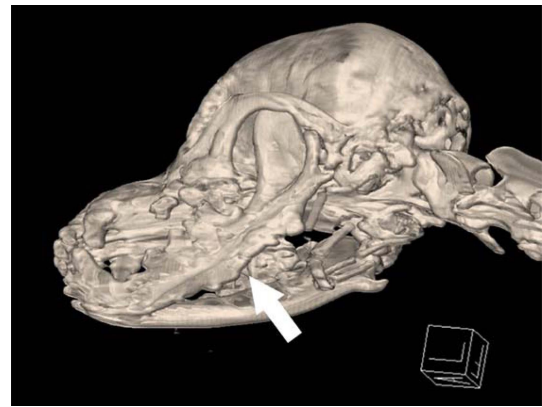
Three-dimensional computed tomography volume-rendered image of the skull view from a left perspective in the patient. The proliferative lesion of the left mandible (arrow), which was located ventral to the mandible had an indistinct border with normal bone.
